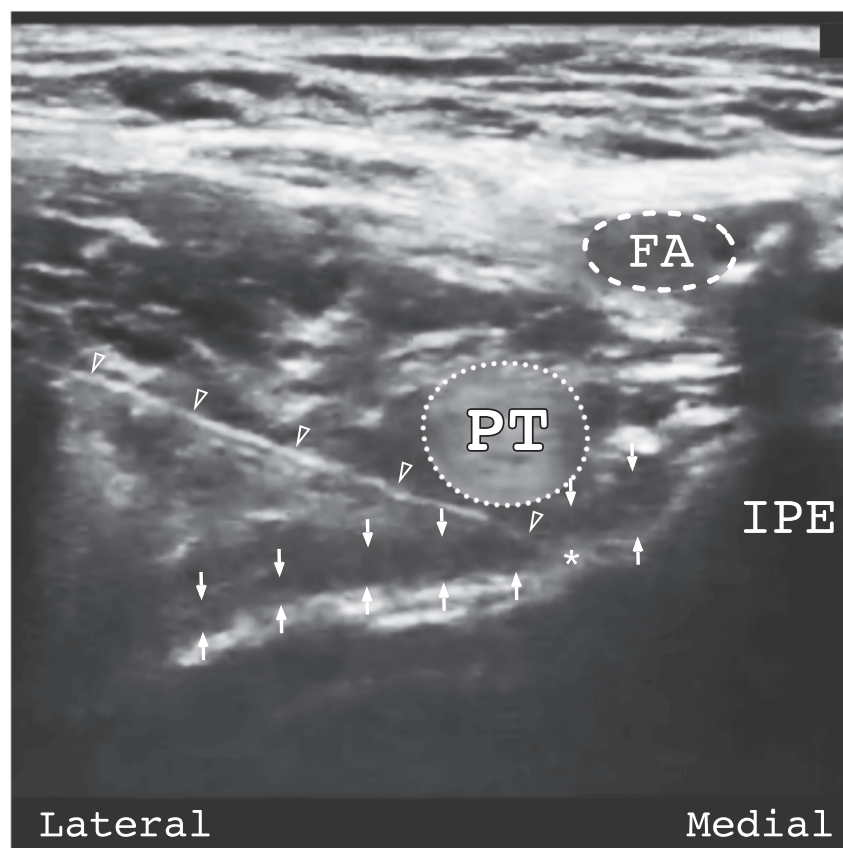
Ultrasound-guided PENG block. The block needle (20 g 90-mm [3.5-in] Quincke lumbar puncture needle) has approached from lateral to medial to contact the ilium at the injection target deep to the psoas tendon and lateral to the iliopubic eminence. Hypoechoic local anesthetic injectate is seen hydro-dissecting (lifting) the iliopsoas muscle group, psoas tendon, and psoas fascia from the ilium confirming spread in the target plane deep to the psoas fascia. Triangles = block needle, asterisk = needle tip, PT/dotted circle = psoas tendon, IPE = iliopubic eminence, down arrows = psoas fascia, up arrows = anterior surface of the body of the ilium, FA = femoral artery.
